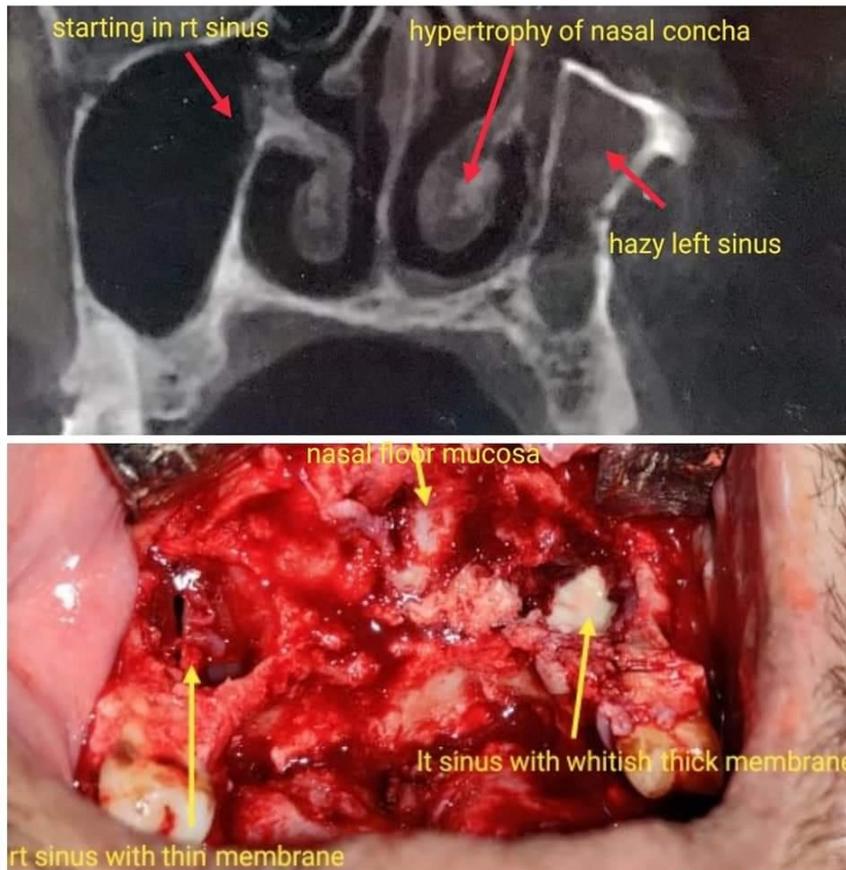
Above CT scan showing hazy left sinus. Below left sinus with whitish thick membrane
